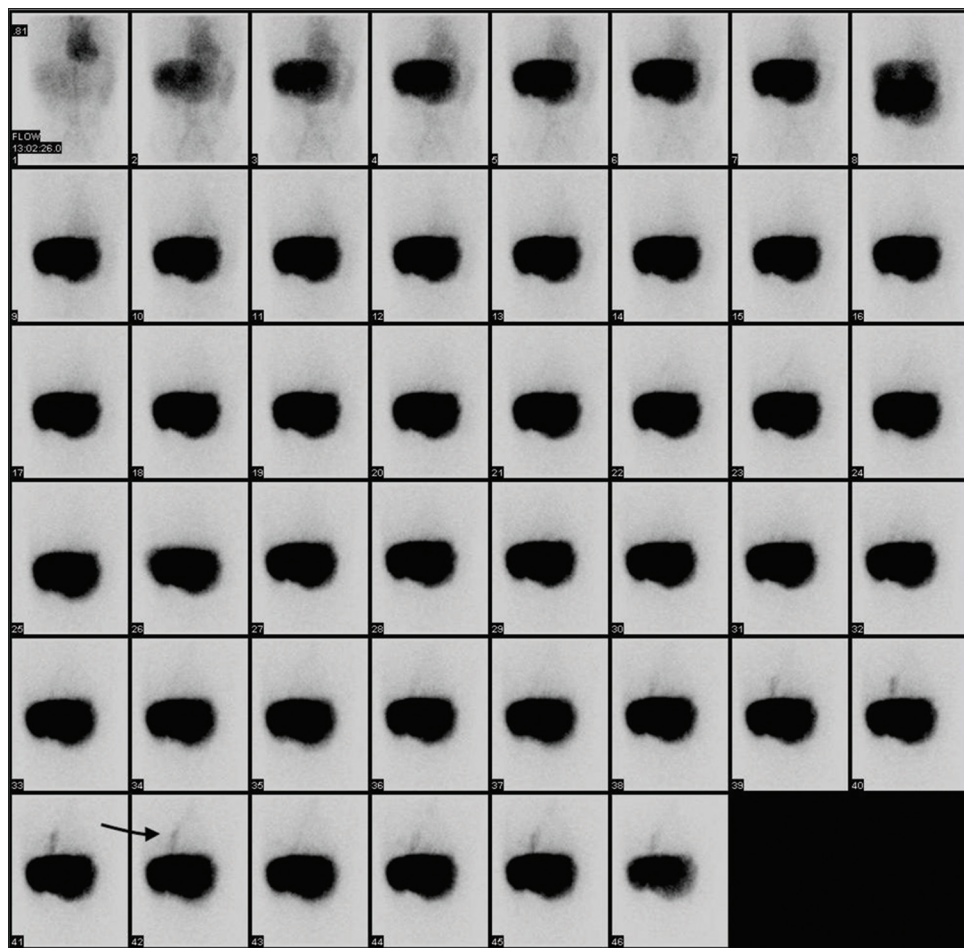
Hepatobiliary scintigraphy was performed with Tc-99 m N-(3-bromo-2,4,6 trimethylphenylcarbamoylmethyl)iminodiacetic acid (mebrofenin). Serial images (1 min/frame for 46 frames) reveal good hepatocyte extraction with linear area of increased tracer uptake in the right hemithorax extending from the superior surface of the liver (arrow) visualized in frame 36–46
